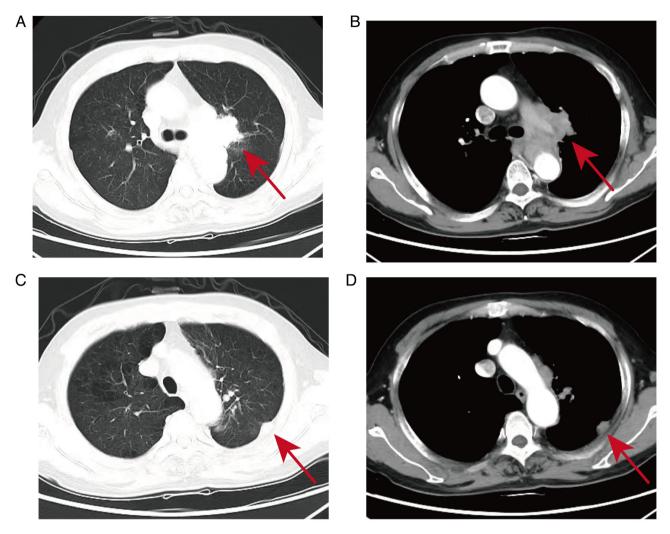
Contrast-enhanced chest CT. (A and B) Multiple ring-shaped enhancing nodules are observed at the left lung hilum, appearing as fused masses, with the largest one measuring ~24 mm in diameter (Red arrow). (C and D) A soft-tissue lesion near the pleura was identified in the dorsal segment of the left mid-lung. It has a clear margin and dimensions of ~15.3x11.9 mm (Red arrow).
